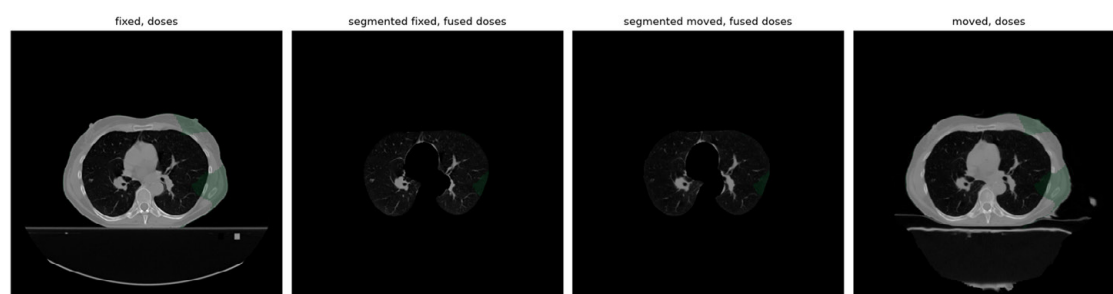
Analysis result – example of the result presentation of applying a mask of doses for selected CT scans from both series.
